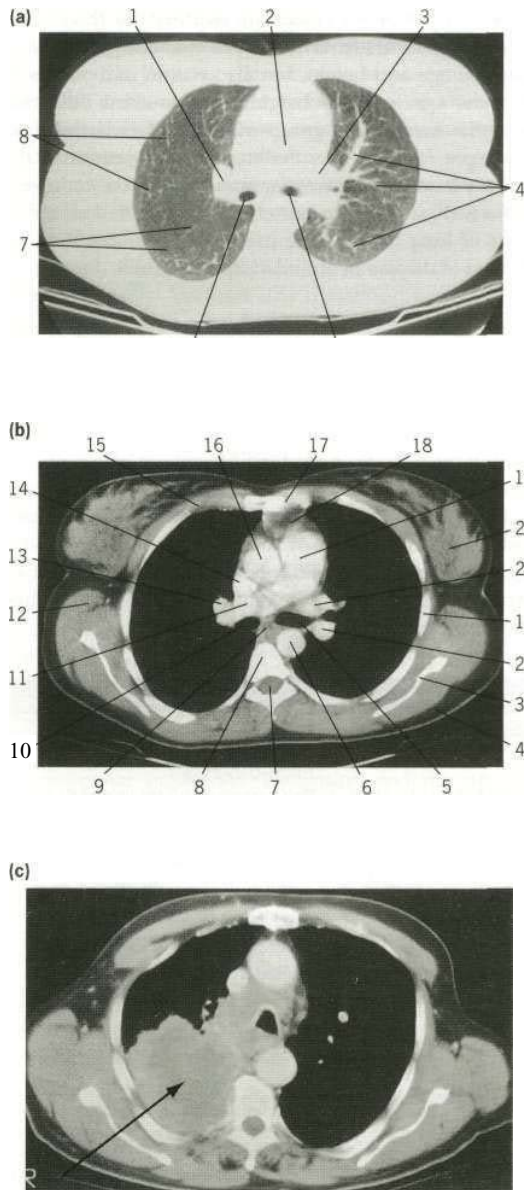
CT scan of the lung.
